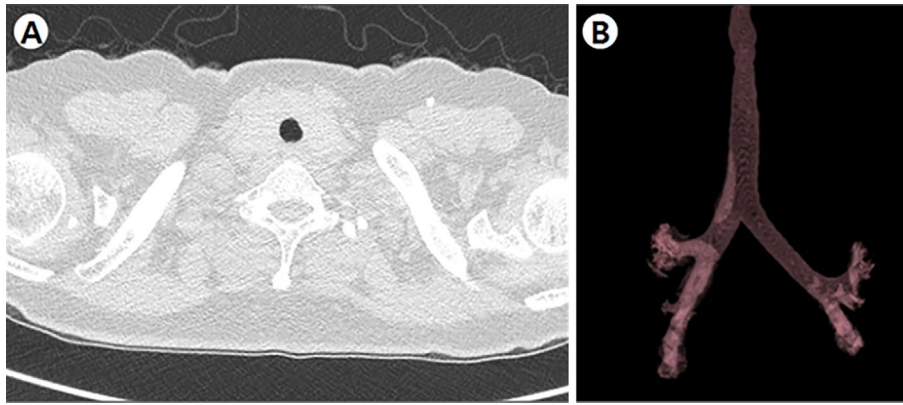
(A, B) Tracheal computed tomography was taken two years after receiving cryotherapy. The trachea shows stable airway patency with the smallest tracheal lumen diameter enlarged to 10.3 mm.
